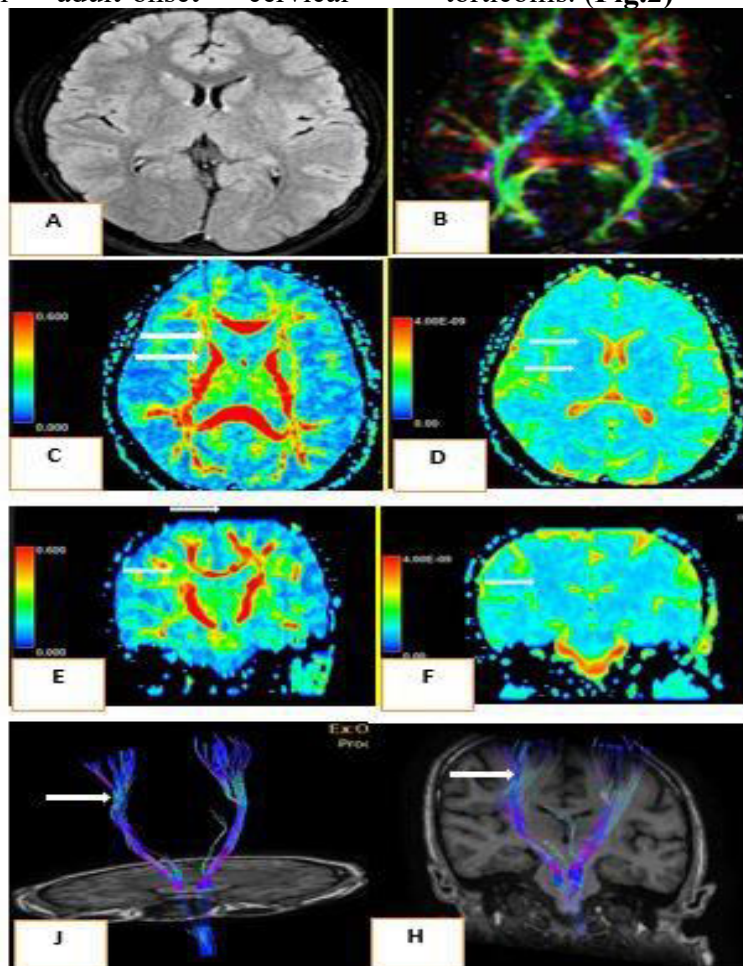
A 31-year-old male patient diagnosed with adult-onset cervical dystonia, complaining from neck pain & torticollis .The conventional axial FLAIR MRI image (A) appears normal and shows no significant abnormalities. The directionally encoded color
